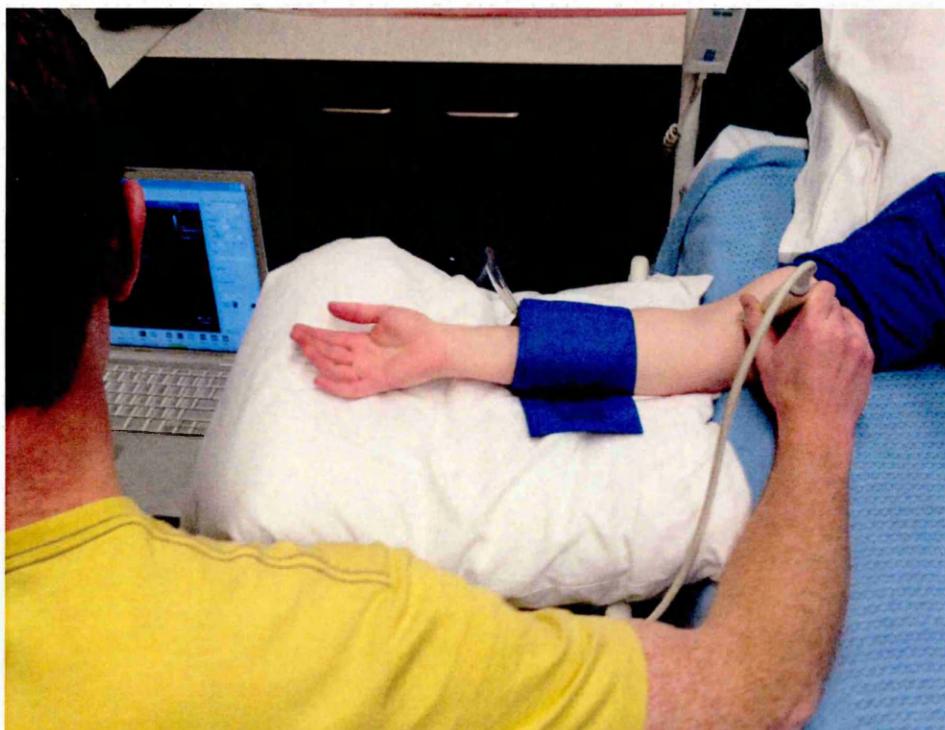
Position of ultrasound probe and rapid inflation cuff for assessments of endothelial-dependent dilatation of the brachial artery using a distal cuff placement.
